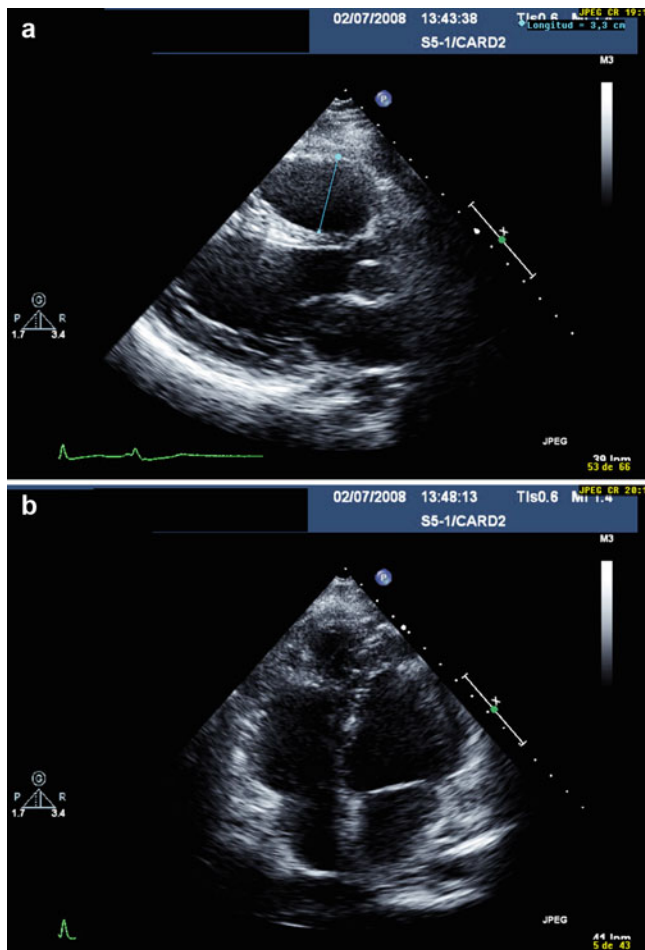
Echocardiographic assessment in a patient with arrhythmogenic right ventricular dysplasia. Parasternal long-axis view (a) and apical four chambers view (b)
